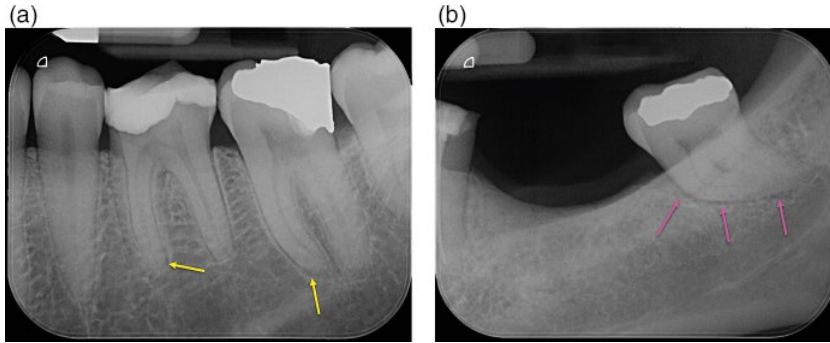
Periodontal ligament space. (a) Periapical radiograph of tooth 36 and 37, demonstrating widening of the PDL space on the mesial roots each tooth (yellow arrows). Both had symptoms of irreversible pulpitis. (b) Periapical radiograph of tooth 37, which is a lone standing tooth and the terminal tooth in the arch. Widening of the PDL space on the mesial aspect of the tooth (pink arrows) is related to traumatic occlusion.
